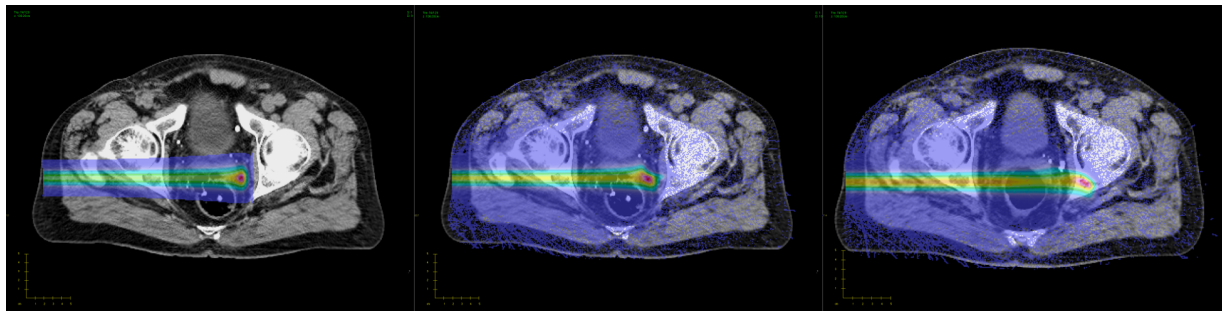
The dose calculated using a simple analytical dose engine of a research TPS CERR (Deasy et al. 2003, Resch et al. 2017) (cf. section 4.1) is shown on the left (note that the used CERR system does not implement pencil beam splitting, thus showing inferior performance than commercial TPSs), while the MC dose for the same PB is shown in the middle (on the planning CT, pCT). The right figure shows the MC dose calculation for the same PB in the case of a substantial anatomical change (on a different CT).
